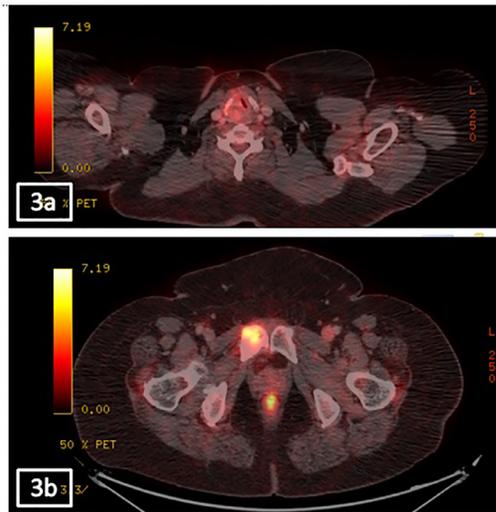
PET scan showing (A) FDG avid thickening at right false vocal cord, right PFS and posterior cricoids region with erosion of right thyroid cartilage (B) skeletal metastases at right pelvic bone.
